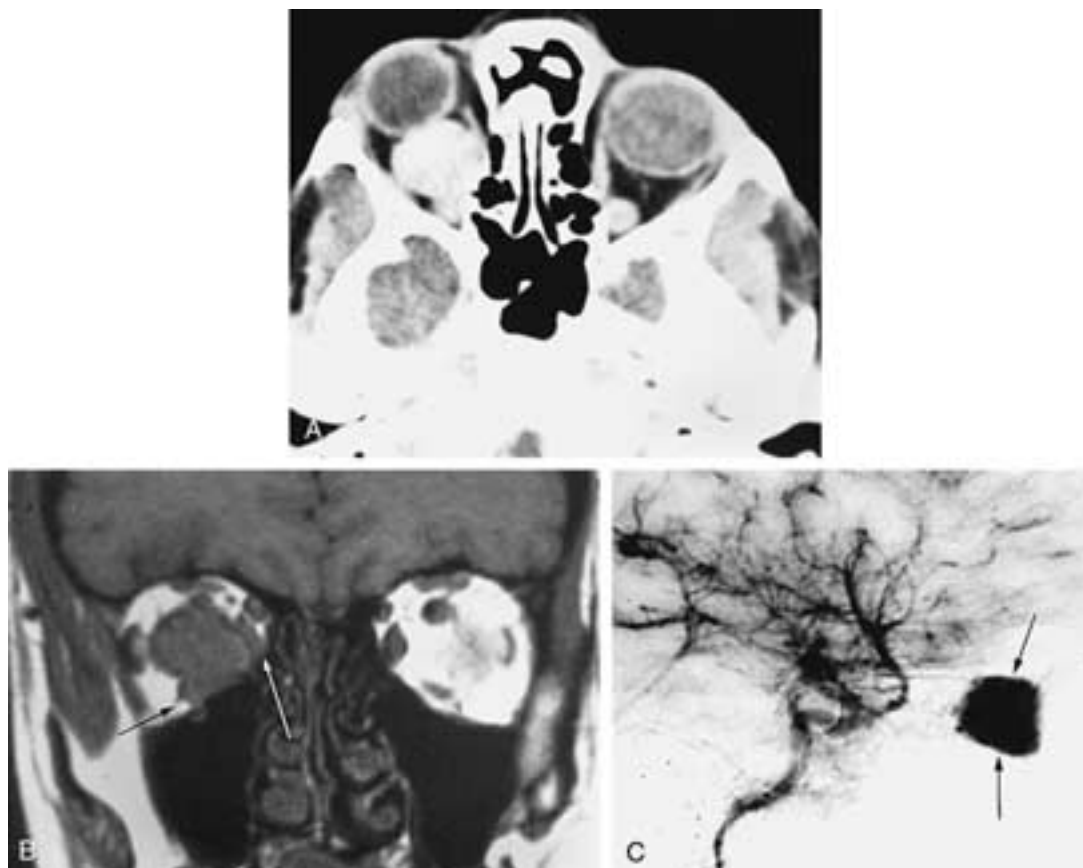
Hemangiopericytoma in a woman. A, Axial contrast-enhanced CT scan shows a large, enhancing mass in the right orbit that scallops the medial wall of the orbit and appears to have an irregular interface with the posterior right globe. B, Coronal T1-weighted MR image shows that the mass is irregular in outline, invades the inferior rectus muscle (*black arrow*), and extends around the left medial rectus muscle to infiltrate the extraconic fat (*white arrow*). C, Sagittal subtraction image of a conventional angiogram reveals marked enhancement of the hemangiopericytoma (*arrows*). This is an important differentiating point from a cavernous hemangioma, which usually shows no contrast pickup or a minimal amount in the venous phase. (Courtesy of Mahmood Mafee, MD, University of Illinois at Chicago, Chicago, Illinois. From Bilaniuk LT. Orbital Vascular Lesions: Role of Imaging. *Radiol Clin North Am* 1999 Jan;37(1):181.)
